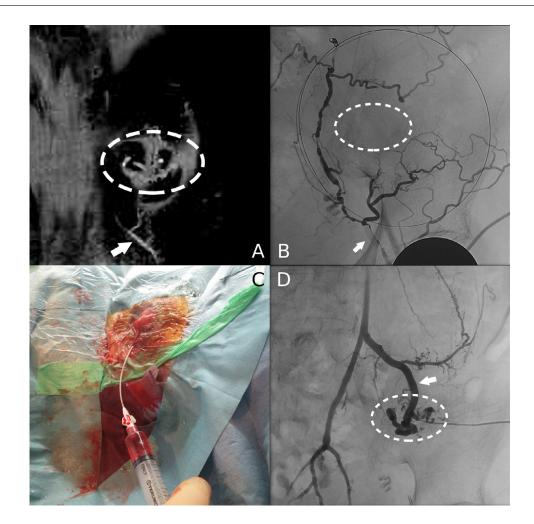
Case2. (A) Preoperative contrast-enhanced computed tomography coronal image (section thickness and interslice interval are respectively 0.625 mm). The superficial epigastric vein (arrow) as drainage vein seems to be continuous to the varices (dotted circle). The diameter is very small. (B) Balloon-occluded retrograde transvenous venography (B-RTV) using a 3.3-Fr micro balloon catheter at the superficial epigastric vein. B-RTV shows numerous epigastric veins, but does not show the varices (dotted circle) in spite of coil embolization and manual compression of collateral drainage veins. (C) Sheath placement after direct puncture of the varices. Ultrasonic-guided puncture is performed. (D) B-RTV after ultrasound-guided direct puncture. The varices (dotted circle) and inferior mesenteric vein (arrow) as an afferent vein are shown.
